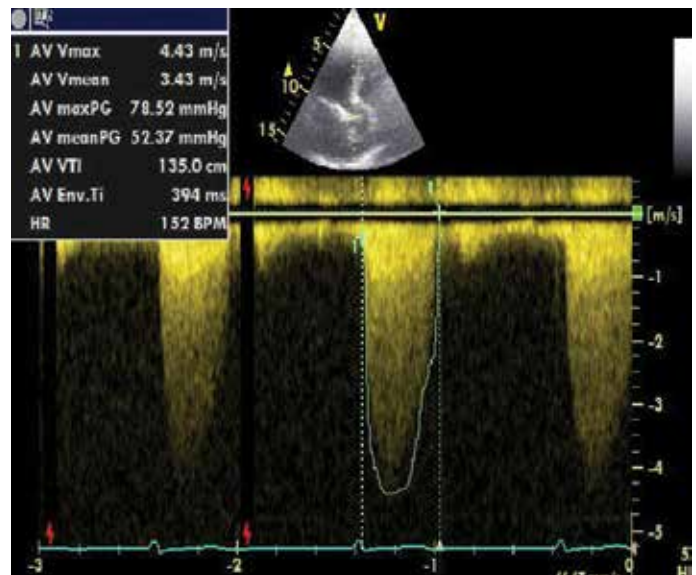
Pre-TAVI continuous Doppler echocardiographic image of the aortic valve
